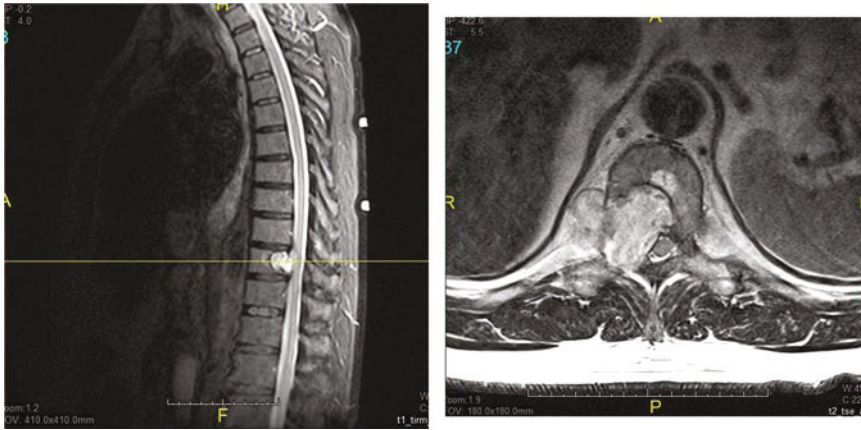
Preoperative MRI of a 59-year-old man who presented to the clinic with signs of myelopathy. The
